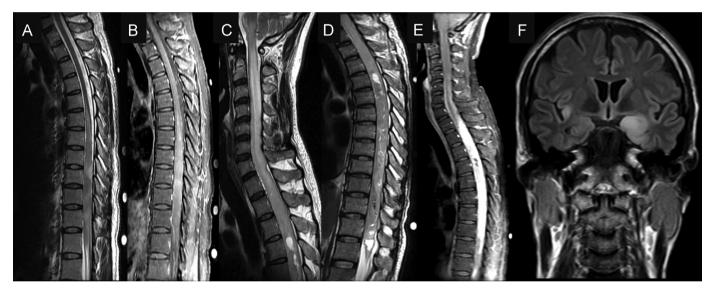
Serial MRI spine and brain from 2010 to 2014. (A) Slight rostral extension of T2-hyperintense lesion to T5/6 junction with increased cord expansion and (B) increased heterogeneous contrast enhancement in 2010. (C, D) Extensive T2-hyperintense lesion from cervico-medullary junction to conus with marked cord expansion, cystic changes and (E) avid contrast enhancement in 2014. (F) MRI brain showing FLAIR abnormalities in the left medial temporal lobe, left caudate nucleus and right insular region in 2014.
